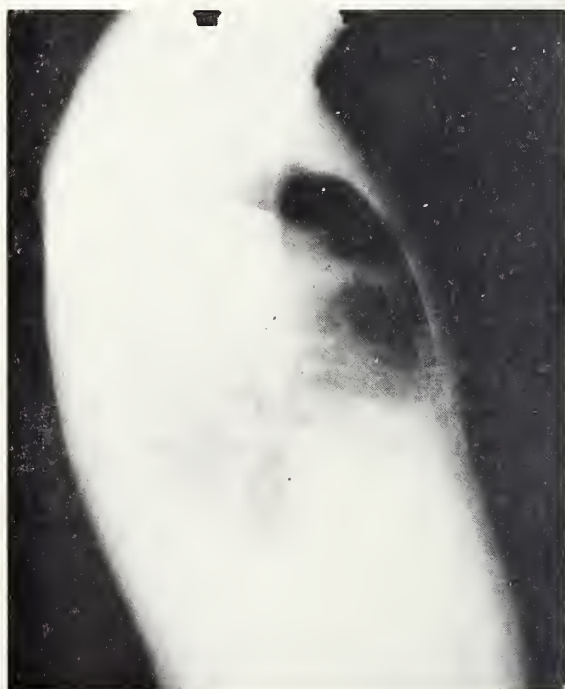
(L.L.) Admission right lateral roentgenogram. Findings similar to 6a.
